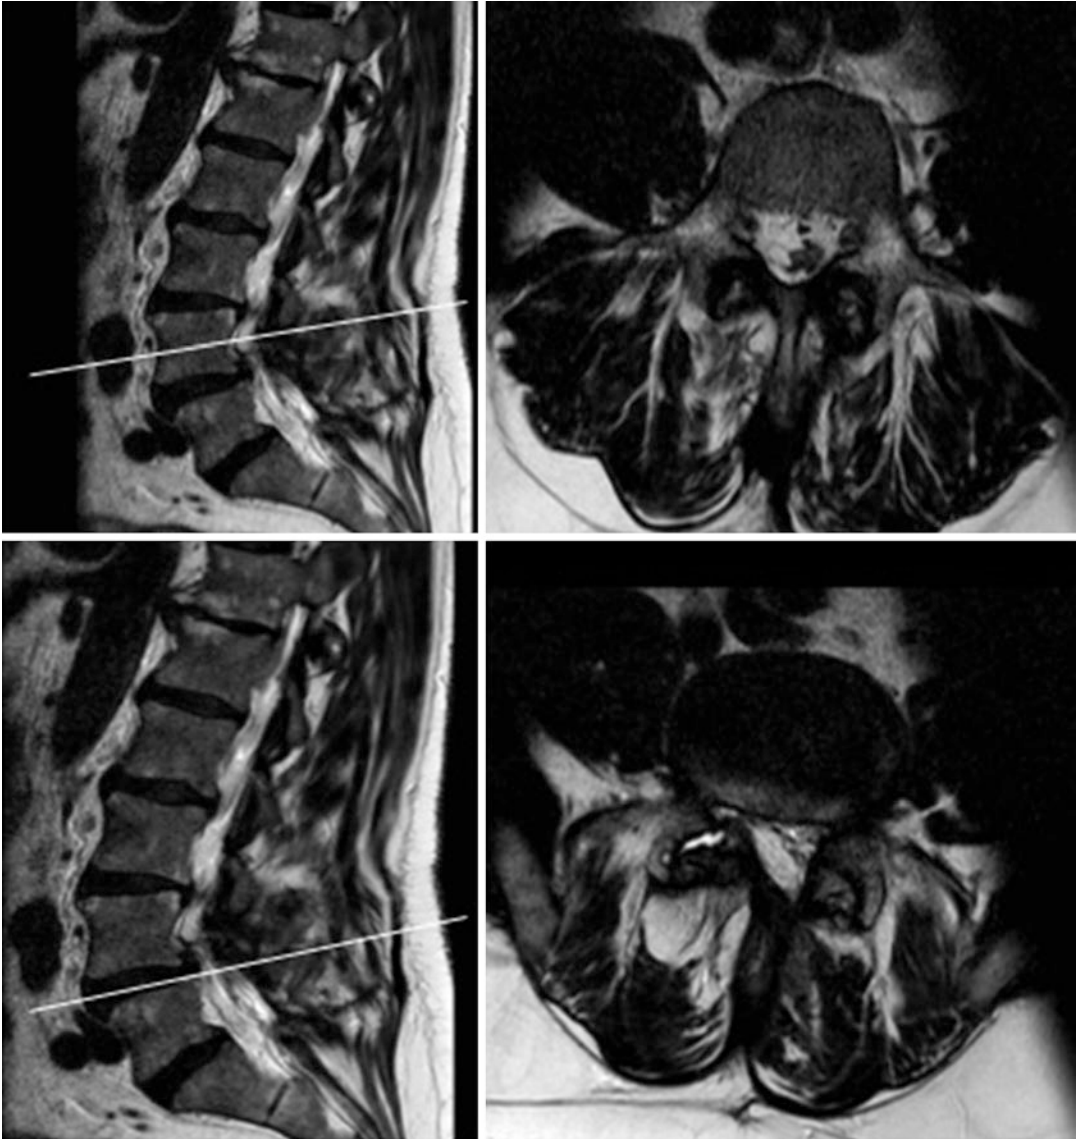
Postoperative T2-weighted MRI in sagittal and axial planes showing effective decompression of both nerve roots by resection of the synovial cyst and recessotomy
